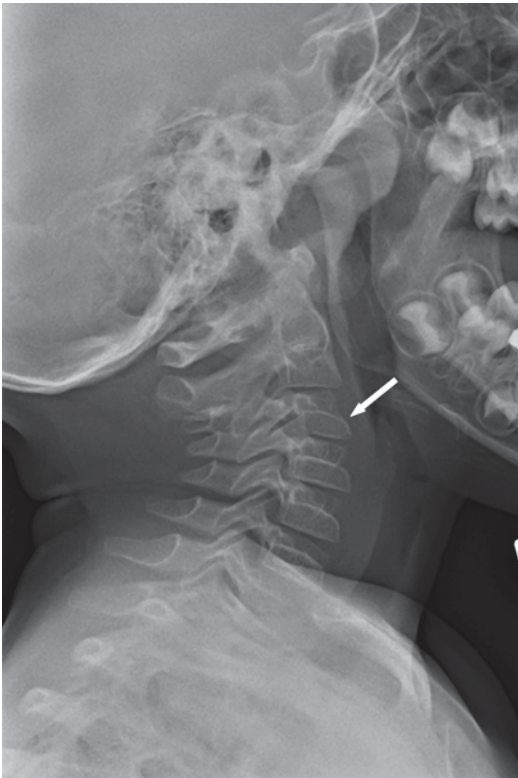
Wedging of C3 (*arrow*). A common finding on lateral plain radiographs
